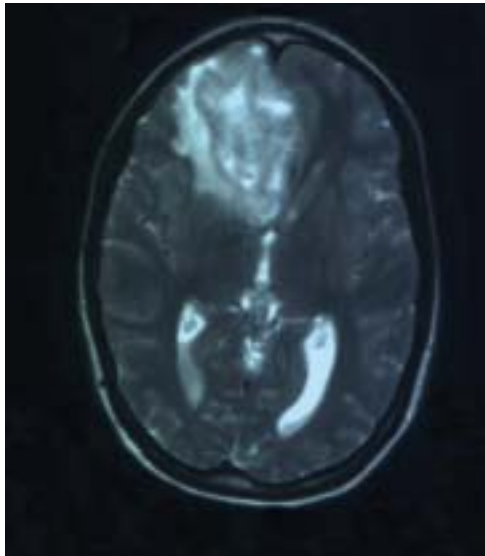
This 20 year old female presented to the neurologists with headaches and vomiting. An MRI scan showed frontal lobe cerebritis and ethmoidal congestion. Note the extensive changes on this T2W image. She was treated with intravenous antibiotics for 3 weeks, improved and was discharged.
